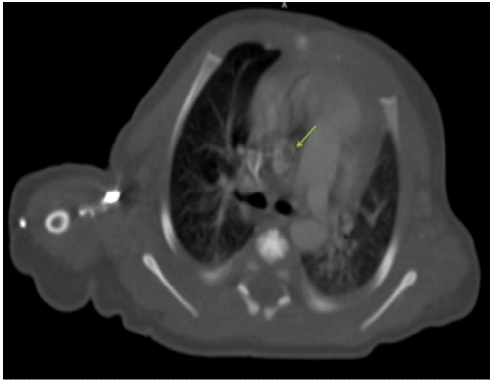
CT angiography with contrast confirmed the aortic mass.
